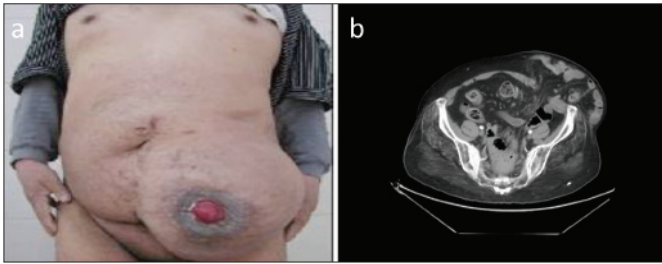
Protruding hernial sac seen in (a) standing position; (b) abdominal CT.
